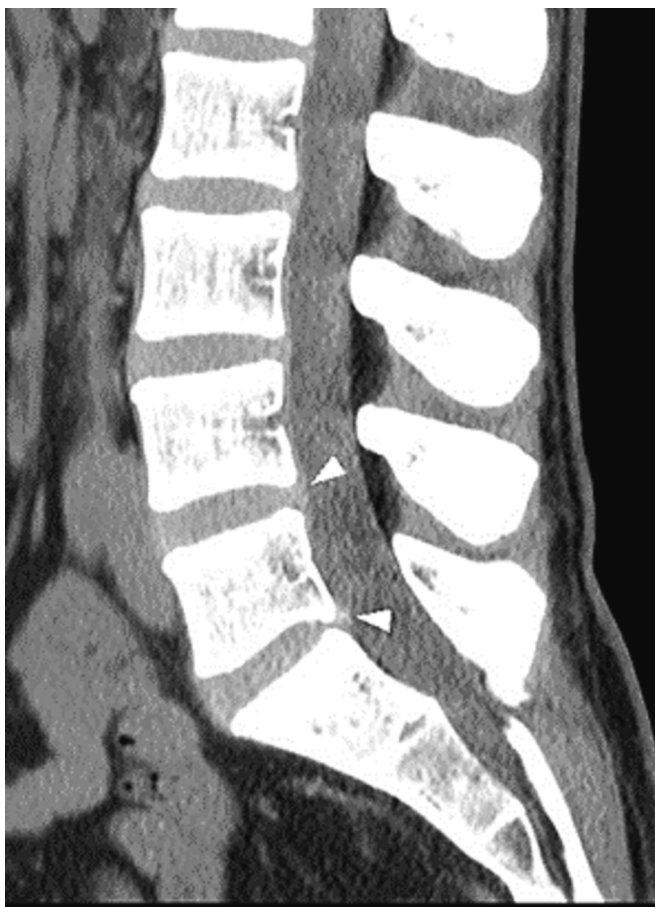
Midsagittal CT-image of the lumbar spine. Discrete bulging of the L4-L5 and L5-S1 discs is seen (arrowheads). No intraspinal mass is detected.
